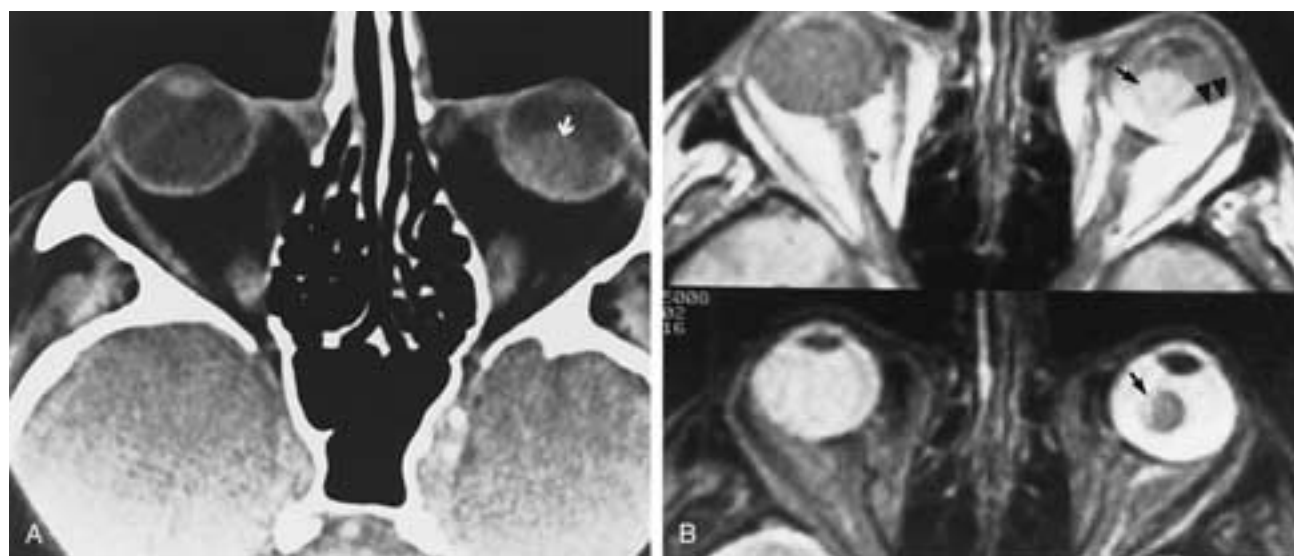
Malignant melanoma of the choroid. A, Axial CT scan shows a mass (*arrow*). B, Axial PW MR image (top) and T2-weighted MR image (bottom) show a mass (*arrow*) and exudative retinal detachment (*arrowheads*). Retinal detachment is distinguished better on MR imaging than on CT.
